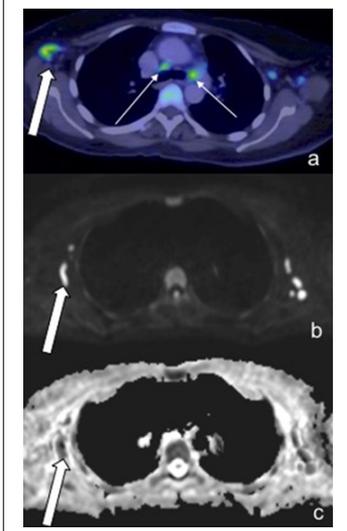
A 57-Year-Old Male Patient Demonstrated Large Pulmonary Lesions with Intense FDG Uptake (a, Thick Arrow), However, these were Barely Detectable on DWI and Misinterpreted as Artefact on ADC (c, Dashed Arrow). Small Hilar Nodes (a, Thin Arrow) were not seen on WB-DWI. Note Increased FDG Uptake in the Vertebra, Sternum and Ribs with Corresponding Restricted Diffusion.
